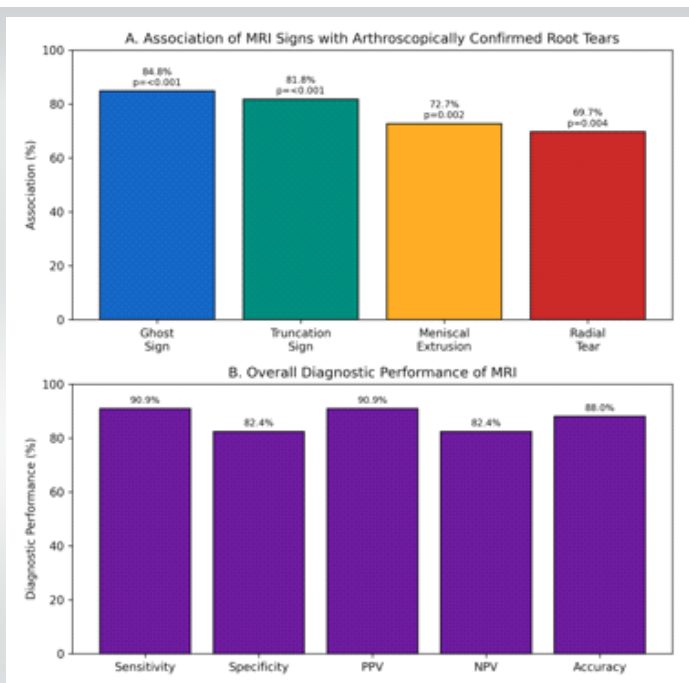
Diagnostic performance of magnetic resonance imaging (MRI) and association of characteristic MRI signs (ghost sign, truncation sign, meniscal extrusion, and radial tear) with arthroscopically confirmed meniscal root tears
